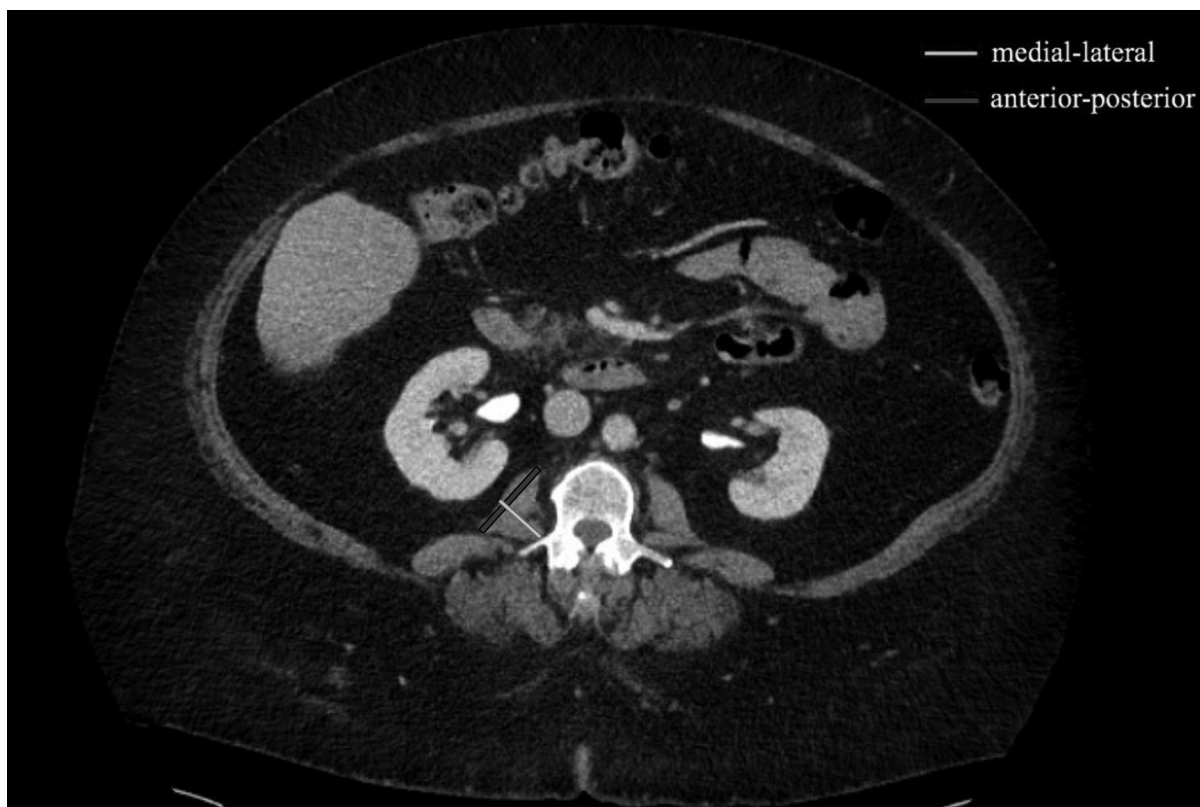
Demonstration of how a single psoas cross-sectional area measurement was performed. This figure was created using an anonymized CT scan cross-section at the L3 vertebrae. The light blue line represents the longest medial-lateral diameter. The red line represents the longest anterior-posterior diameter. These diameters were then multiplied together and normalized by patient height<sup>2</sup> (m<sup>2</sup>).
